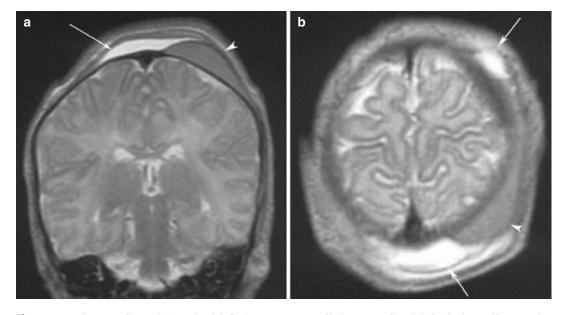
Brain MRI. Coronal (a) and axial (b) images reveal the caput succedaneum (*arrow*) with crossing the suture line and the cephalhaematoma (*arrowhead*) without crossing the suture line. The low signal intensity of the cephalhaematoma suggests the subacute haematoma.
